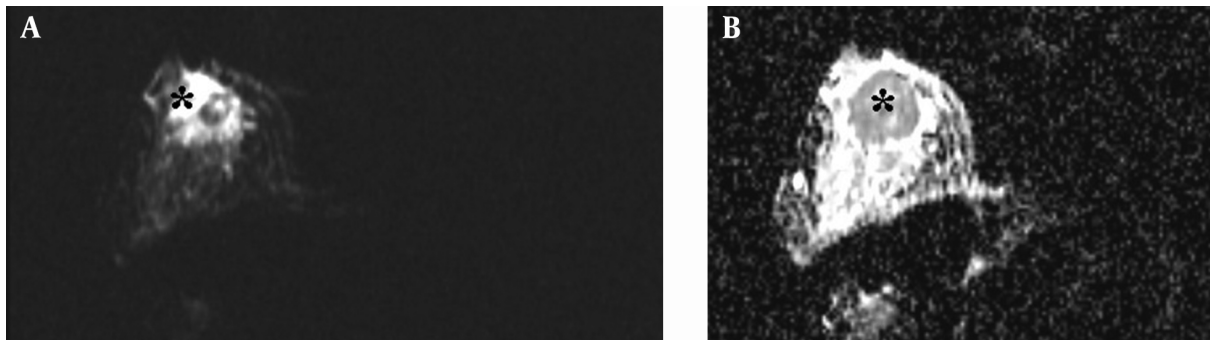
A, Diffusion-weighted MRI at b value of 800 sec/mm² showed hyperintense signal intensity of the mass (black star); B, The lesion was hypointense on ADC map and consistent with restricted diffusion (black star).
